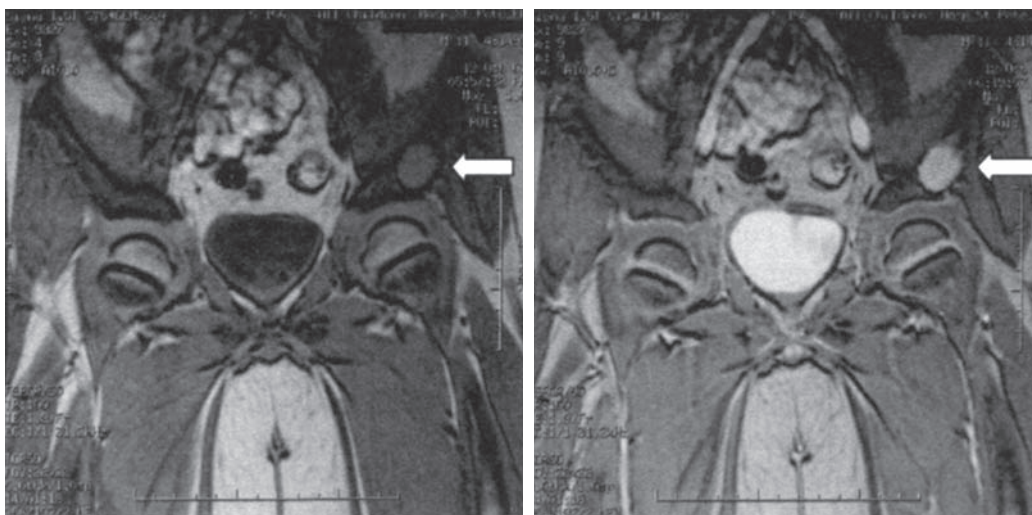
■ Demonstration by gradient recall echo magnetic resonance imaging of a FGF23 producing hemangiopericytoma in the left iliac wing of an 11-year-old boy with tumor-induced rickets. (From Shulman, D. I., Hahn, G., Benator, R., et al. (2004). Tumor-induced rickets: usefulness of MR gradient echo recall imaging for tumor localization. *J Pediatr*, 144, 381–385.)
